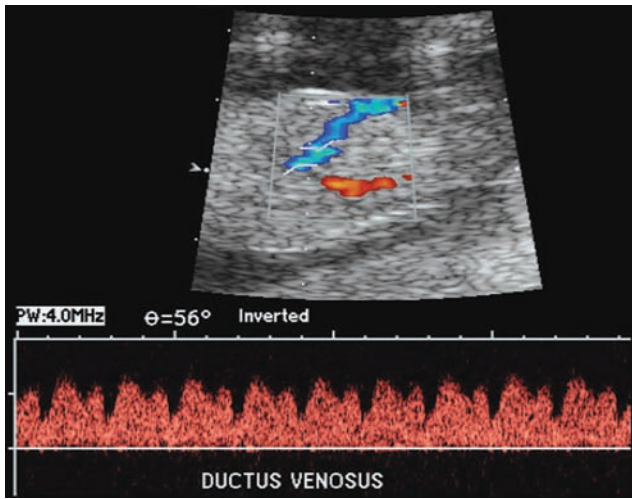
Triphasic forward Doppler flow waveform in the DV. It is directed toward the heart through the whole cardiac cycle. A nadir of forward flow is observed during atrial contraction.
